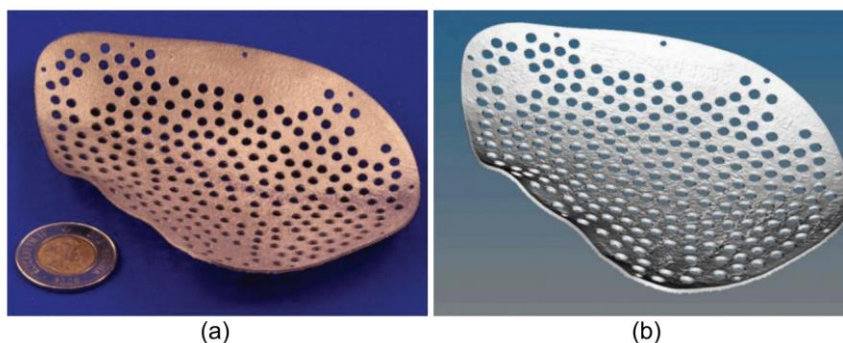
(a) titanium cranial plate, with (b) CT scan data at 80 kVp (GE Ultra, 150 μm , 16 s scan).
